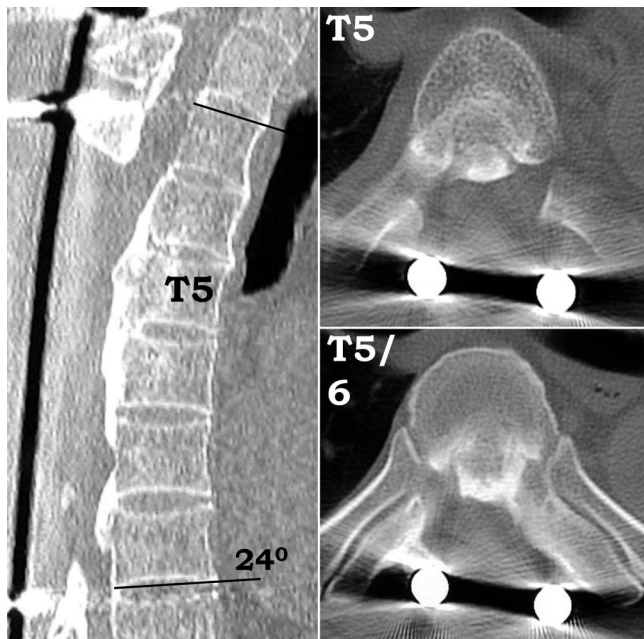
Radiographic images obtained 15 years after the second surgery. A midsagittal reconstruction of CT (left) shows no evidence of the progression of residual OPLL. Thoracic kyphosis at T3–T8 remains 24°. Axial CT images at T5 (right, upper) and T5–T6 (right, lower) show the residual OPLL.
